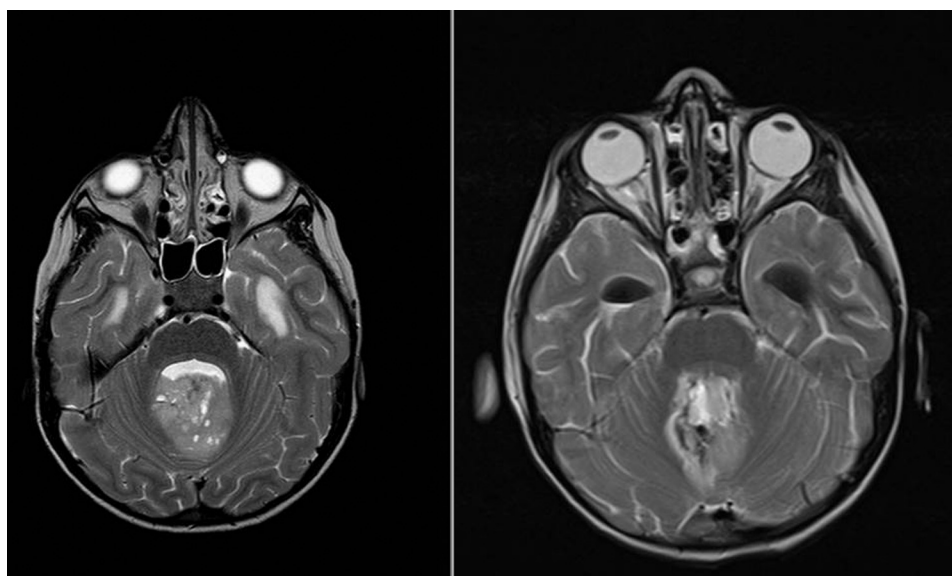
A sub-total resection: on the left the basal MRI (Flair sequence).
